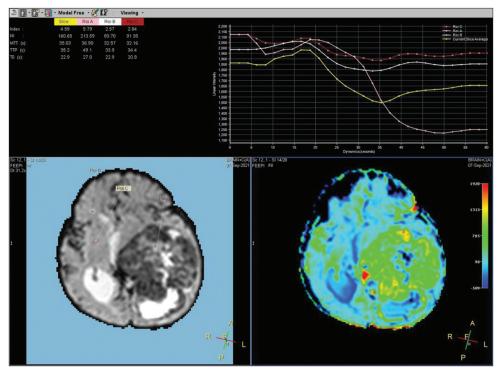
MRI brain perfusion image showing excessive vascularity of the tumor.
